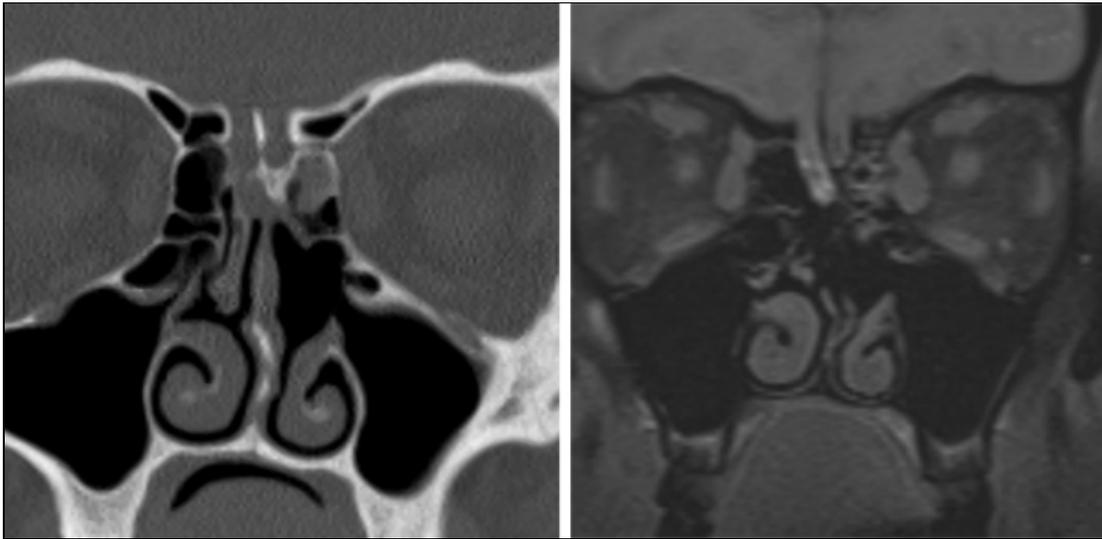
45 yr old woman with prior left sided CSF leak at cribriform plate, repaired. Now with right-sided rhinorrhea. (Left) Coronal sinus CT shows defect at right cribriform plate, with soft tissue filling the olfactory groove. (Right) Coronal fat saturated T1 weighted MR image after intrathecal administration of 0.5 ml gadolinium contrast shows high signal intensity CSF pooling in the olfactory groove, confirming the site of the leak.
